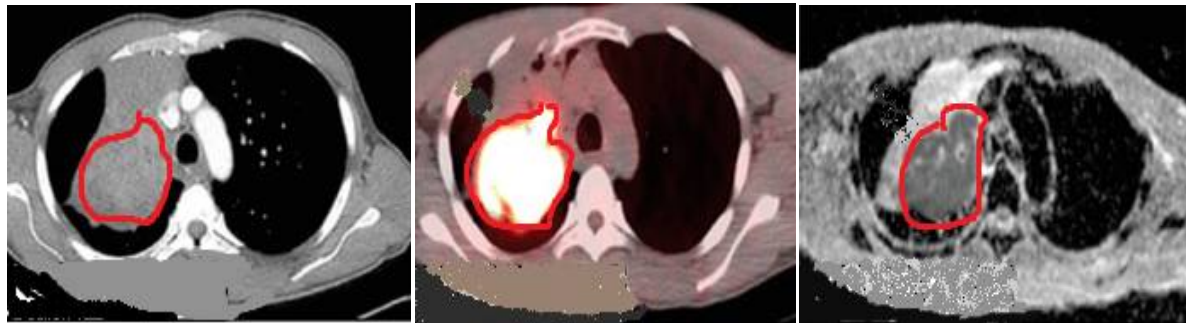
a. CT Image of lung cancer b. PET/CT Image of lung cancer c. DW-MRI Image of lung cancer
